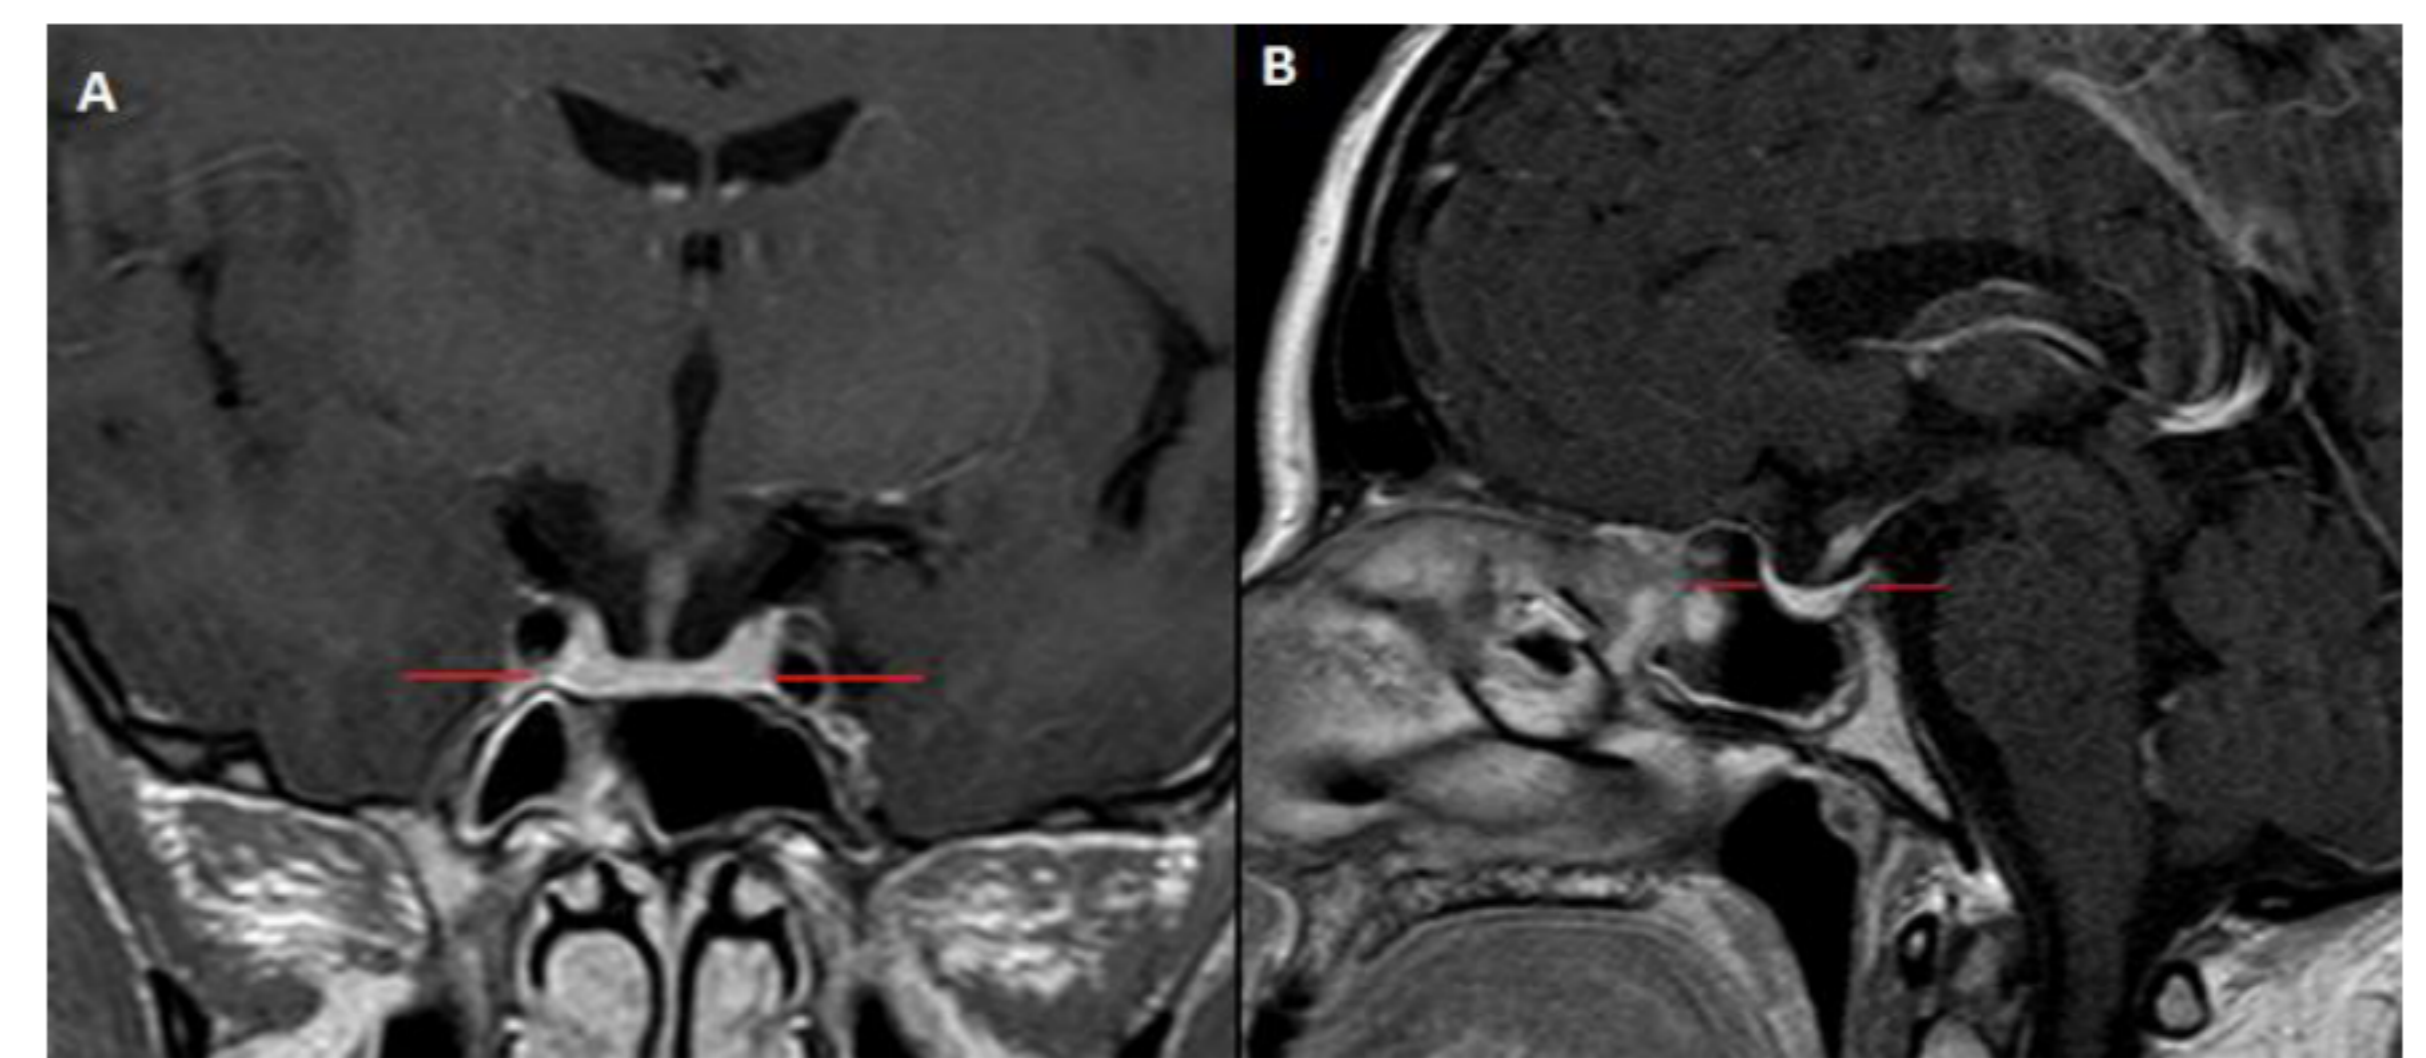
MRI obtained at 6 months after corticosteroid treatment showed marked decline in the size of pituitary gland with post-contrast T1-weighted coronal (A) and midsagittal (B) images.
